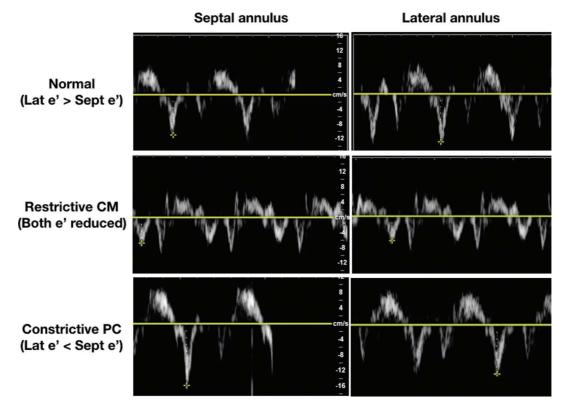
Tissue Doppler imaging in restrictive cardiomyopathy and constrictive pericarditis. Normally, lateral e' velocity is greater than septal e', due to tethering of the septal annulus to the septal wall. In restrictive cardiomyopathies, the e' velocities at both septal and lateral annuli are decreased. In constrictive pericarditis, the septal e' exceeds lateral e', due to inflammation and thickening of the pericardial sac, which slows movement of the left ventricular lateral wall.
